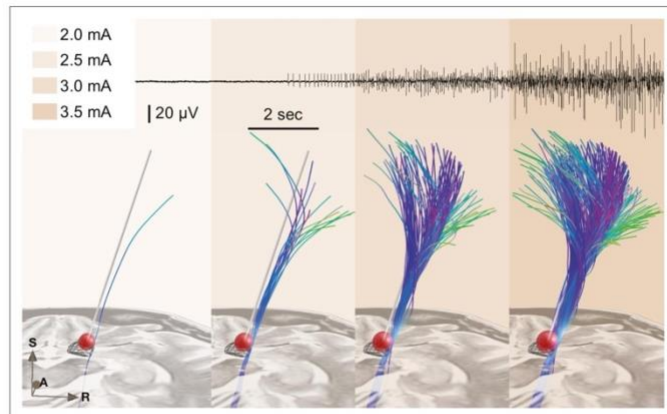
Example of test stimulation setup (also see [Figure 4—video 1](#) for the demonstration of a real-time application). A simplified stimulation volume is modeled based on the applied test stimulation parameters following the approach of [Dembek et al., 2017](#). From a set of predefined fiber tracts representing the internal capsule (without hyperdirect components; [Petersen et al., 2019](#)) that were registered to patient space, fibers passing through the volume were visualized in real time. Alternatively, tractograms obtained based on diffusion MRI of the individual patient data or normative connectomes could be used. The top panel shows needle electromyography (EMG) activity that was recorded within clinical routine from the brachioradialis muscle during stimulation in the same patient. Colors represent stimulation amplitude. After a preliminary exploratory analysis of the k_2 parameter from Dembek's formula, a value of 0.8 was used for the shown example.
